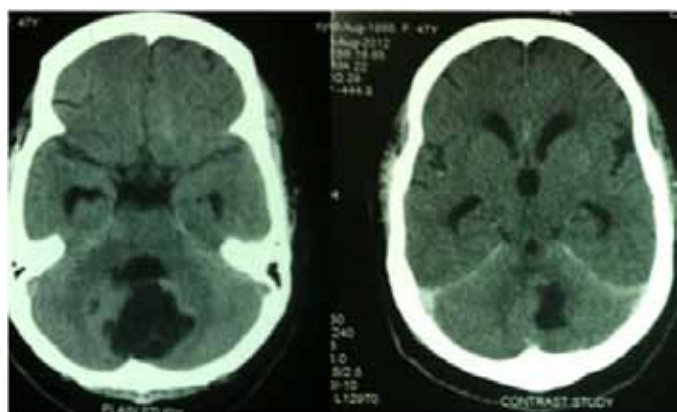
Plain and contrast computed tomography images showing lesion with mixed density in the posterior fossa with evolving hydrocephalus.
